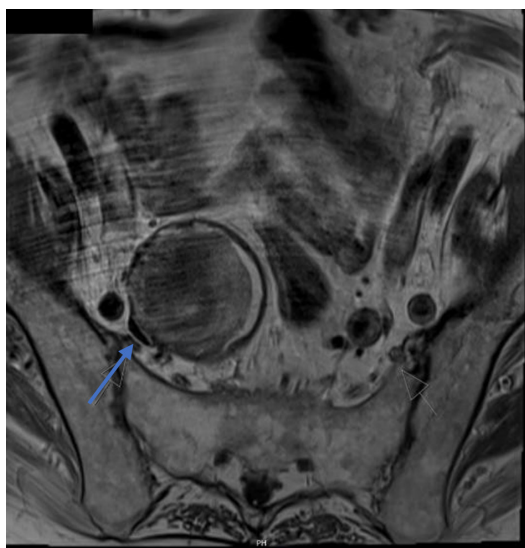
T1 Axial MRI Pelvis without contrast. MRI of pelvis without contrast showed right internal iliac artery aneurysm measuring 10.6 cm craniocaudal dimension and 6.5 x 6 cm transverse dimension (arrow).
